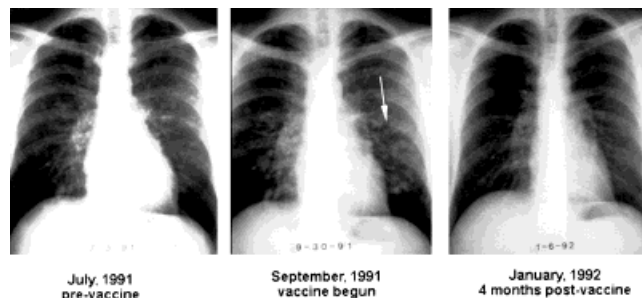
Regression of lung metastases in patient #20063. Multiple lung metastases are seen in July, 1991, most prominently in the left lower lobe (arrow), which had increased in size and number in the September, 1991 x-ray. Four months after beginning DNP vaccine treatment, the metastases have completely regressed.
